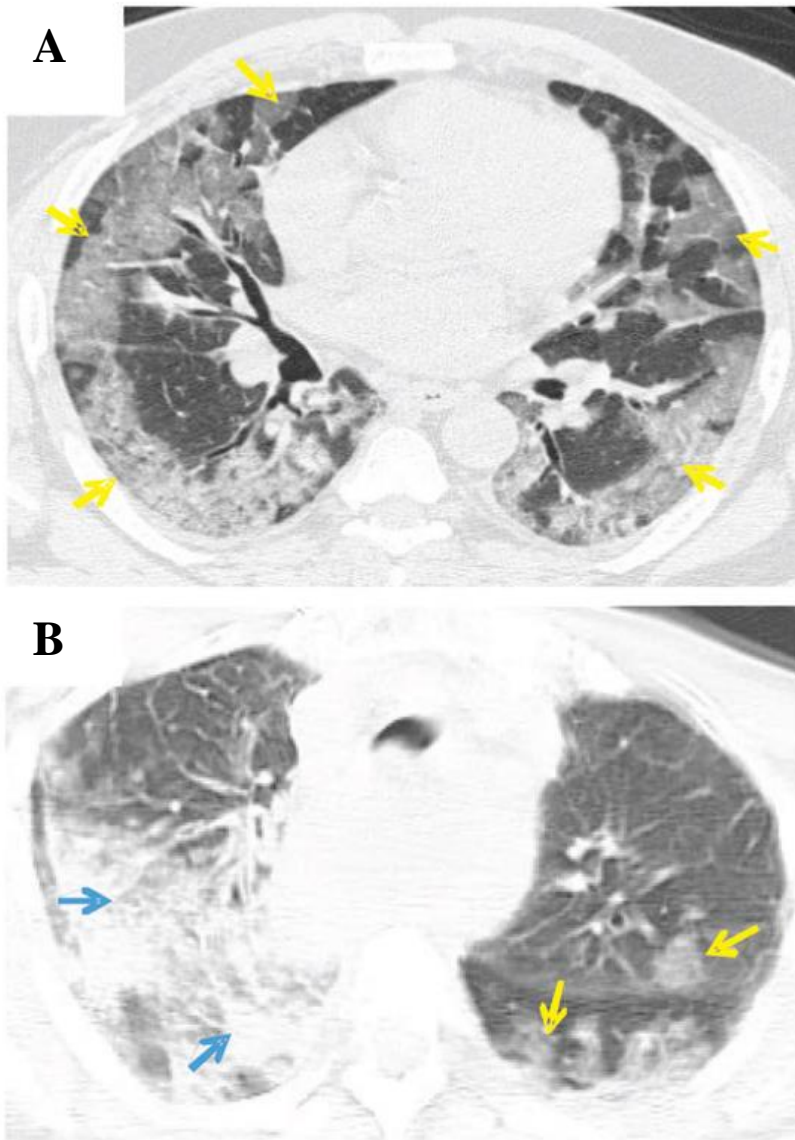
Computed Tomography Scans of Fatal Influenza-Bacterial Co-infections.
